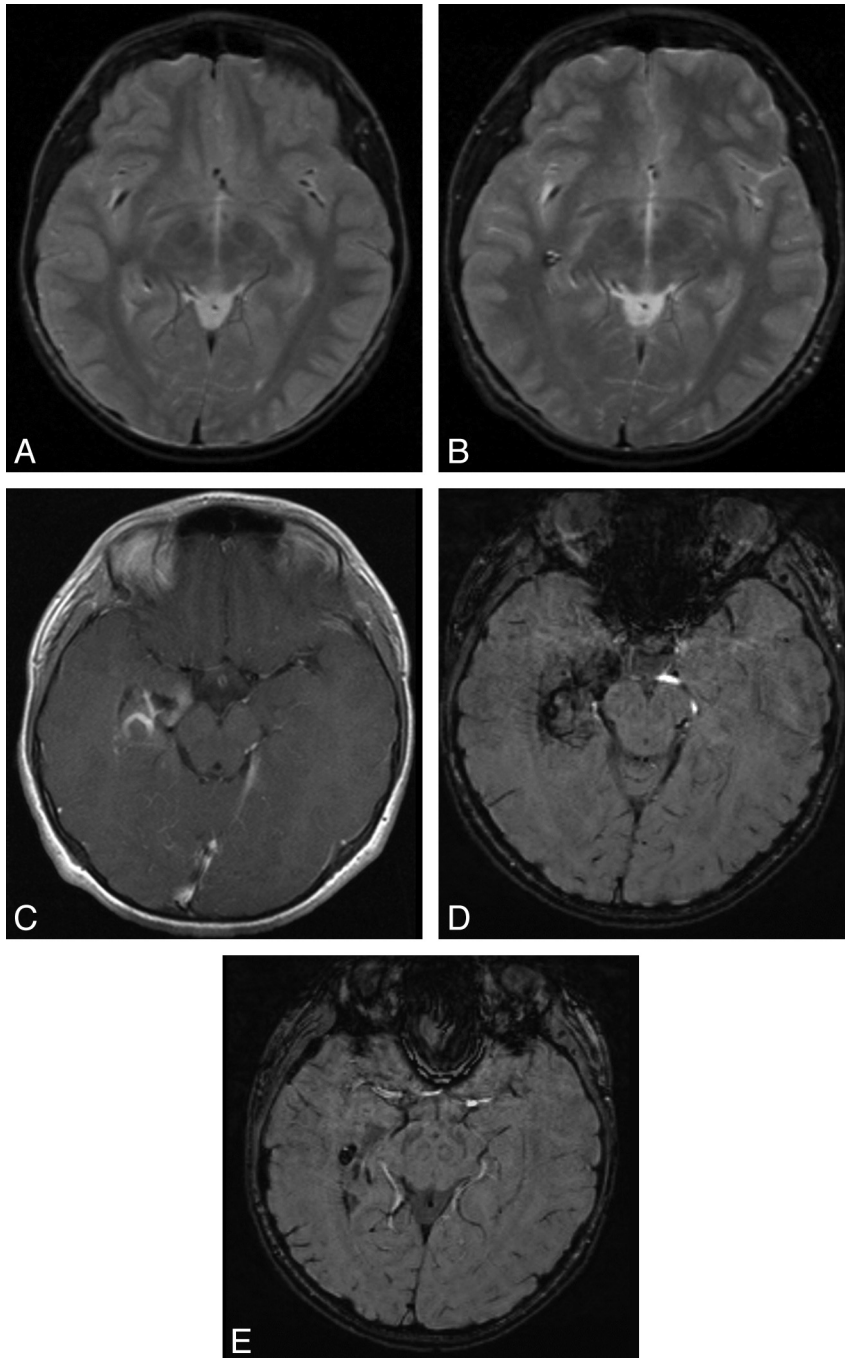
DVA with a sporadic CCM, which enlarged with time. *A*, Initial T2 SE of a 14-year-old boy shows only a small subtle focus of low signal intensity. *B*, Repeat MR imaging 2 years later shows a more typical reticulated or popcorn-like appearance of a CCM. *C*, The associated DVA is best seen at a slightly lower level (T1 postgadolinium). *D* and *E*, The DVA and CCM are clearly demonstrated on SWI on the second study.
